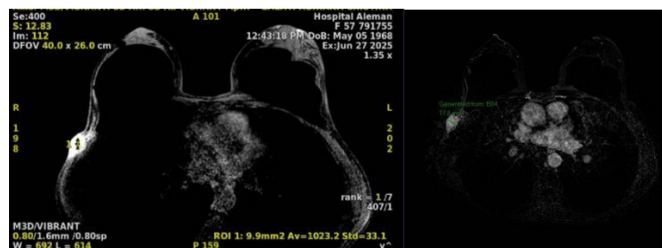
Nodular lesion on MRI.
